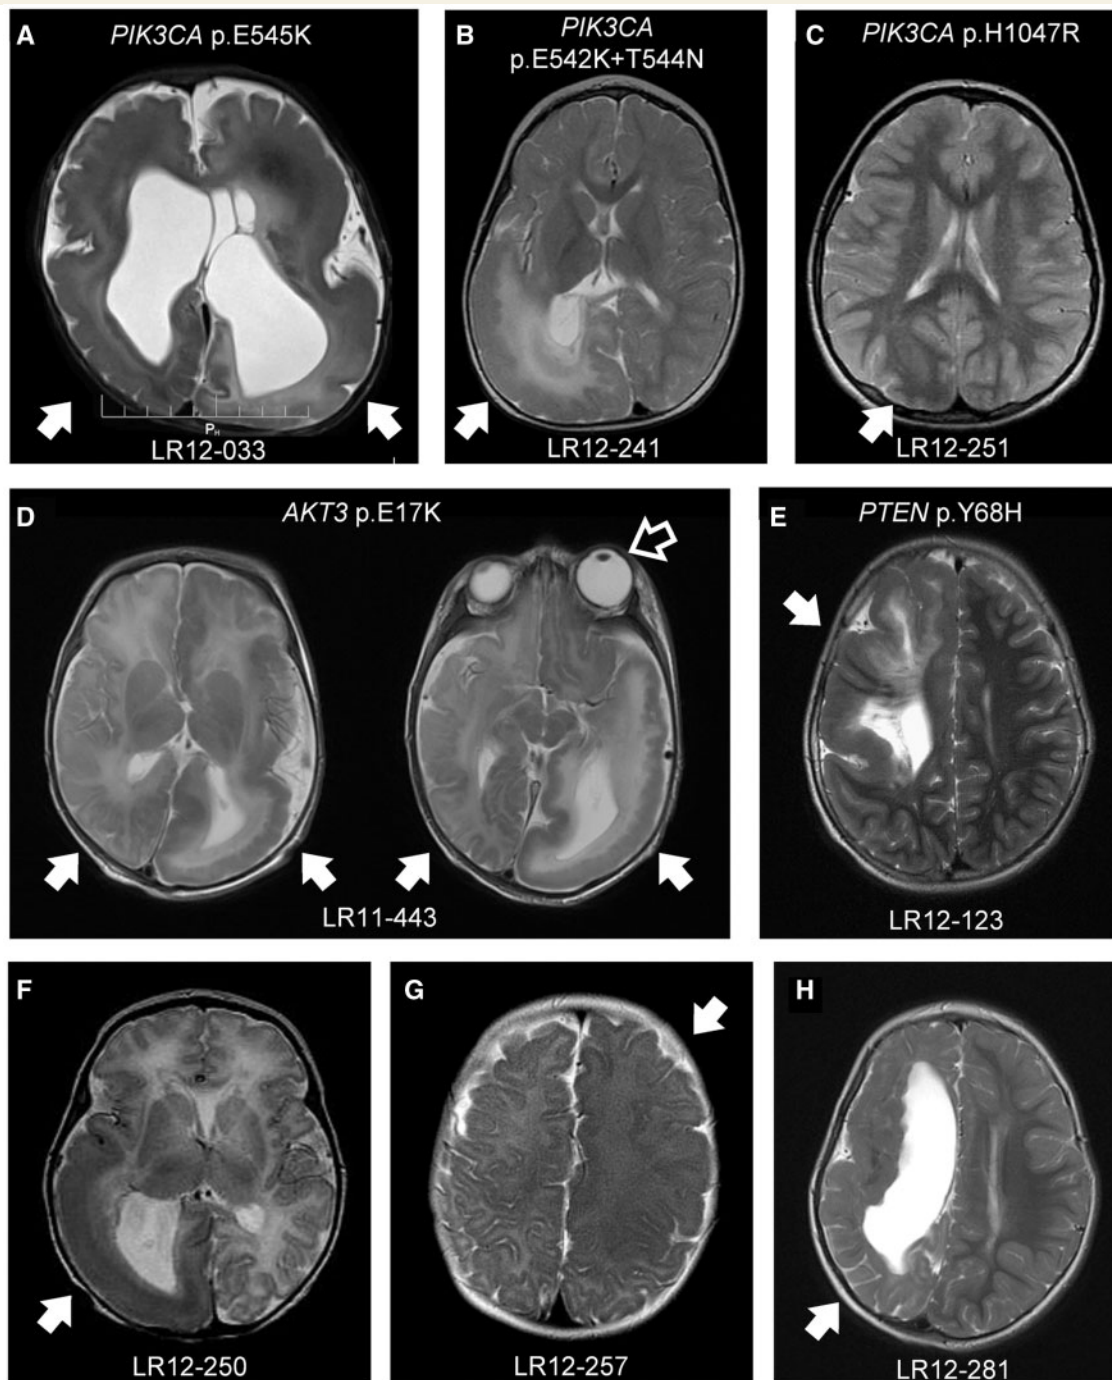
MRI findings in dysplastic brain malformations with and without detected mutations. T₂-weighted images are shown. Filled arrows indicate regions of abnormality, including ventricular enlargement, variable degrees of cortical dysmorphism (i.e. pachygyria, polymicrogyria, or undersulcation), periventricular nodular heterotopia, abnormal white matter signal, and/or widening of the extra-axial space. (A) DMEG; (B, E–H) HMEG; (C) FCD type IIa; (D) bihemispheric asymmetric dysplasia. The open arrow indicates unilateral ocular enlargement in Patient LR11-443, who exhibits severe abnormality of the left hemisphere (HMEG) along with milder abnormalities of the posterior portion of the right hemisphere.
